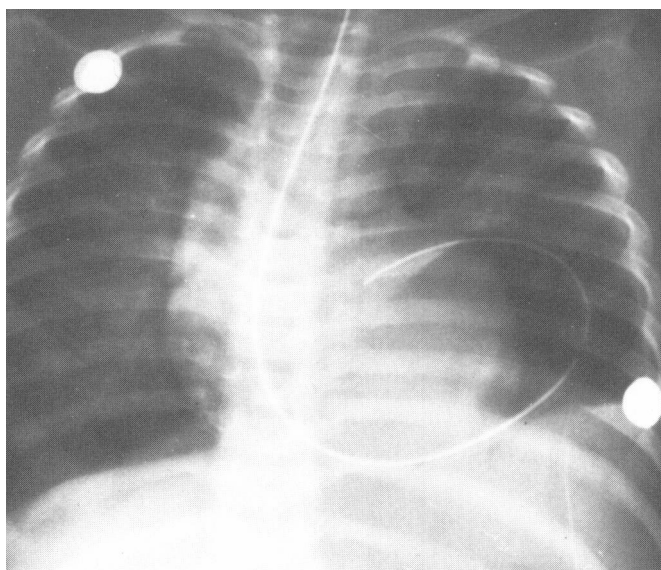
a, b*. This two-year-old boy, after being struck by an automobile, presented to the Emergency Room with respiratory distress and decreased breath sounds on the left. The admission chest radiograph (Figure 8*a*) revealed a large radiolucency in the left lung base with atelectatic changes in the left upper and left mid lung zones. There is also a mediastinal shift to the right. Following passage of a nasogastric tube, a repeat radiograph (Figure 8*b*) confirmed the suspected stomach herniation through a ruptured left hemidiaphragm.
